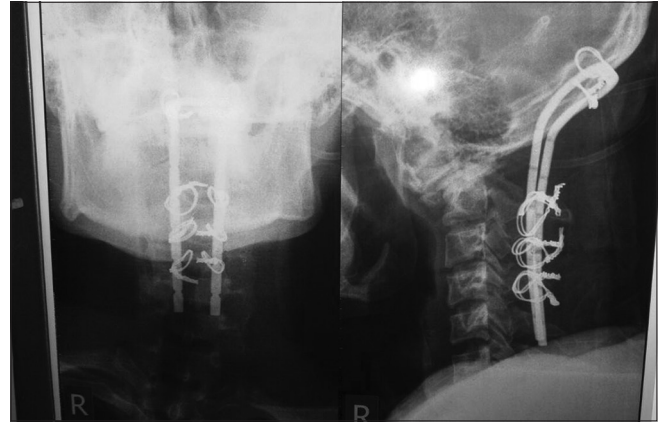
Postoperative cervical X-ray, anteroposterior view (left), and lateral view (right).
